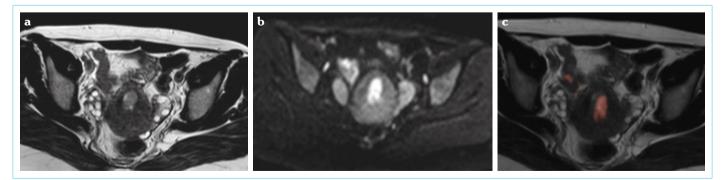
Axial oblique T2WIs (a) shows relatively thickened endometrium with intermediate signal intensity. An intact junctional zone is noted. Axial oblique DWI is present at a b value of 1000 (b) and a T2/DW fused image (c) shows restricted diffusion with the interruption of the junctional zone posteriorly, suggesting superficial myometrial invasion which was confirmed by pathology, i.e., Stage IA
